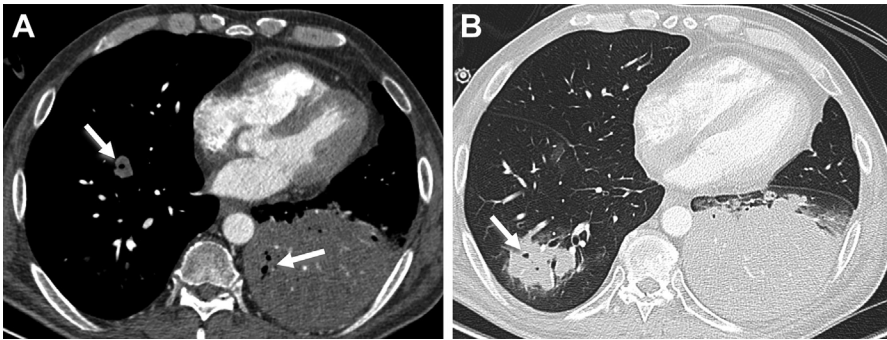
Chest CT of pulmonary nocardia infection in a 55-year-old man receiving systemic chemotherapy. (A) Low attenuation consolidation in the left lower lobe and middle lobe nodule both containing bubbles of air at sites of necrosis (arrows). (B) More inferior CT section shows a consolidative mass in the right lower lobe which also contains a focus of necrosis.
